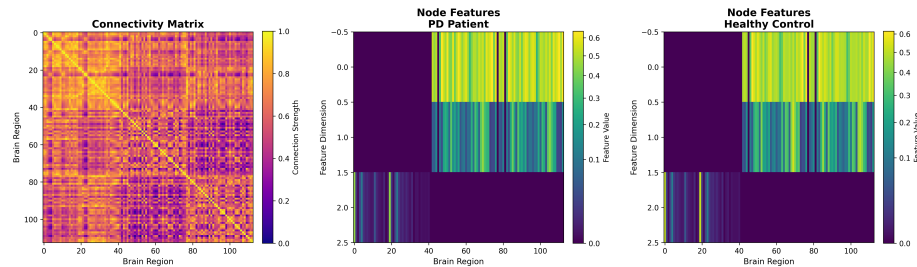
Examples of MRI graphs built during data preprocessing
